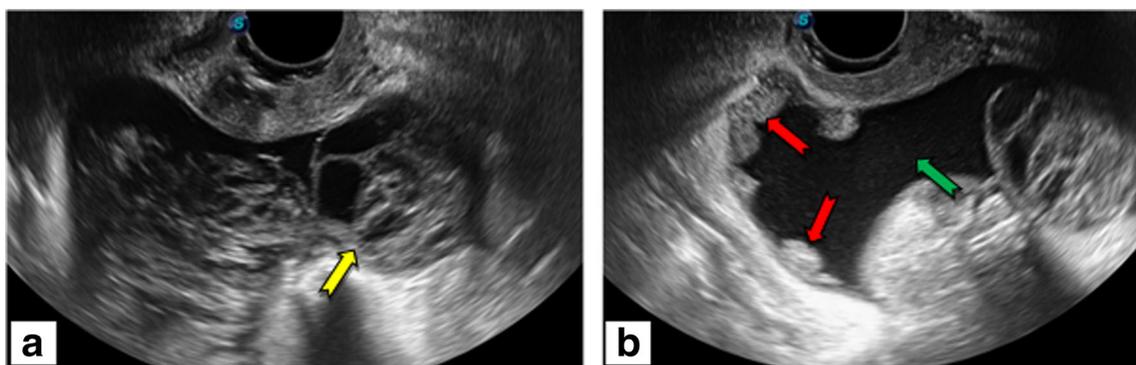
a Transvaginal ultrasound demonstrates a left adnexal complex cystic mass (yellow arrows) of solid and cystic components and multiple thick internal septations. b Turbid ascites (green arrow) and multiple peritoneal deposits (red arrows) were present in the abdomen. The mass
